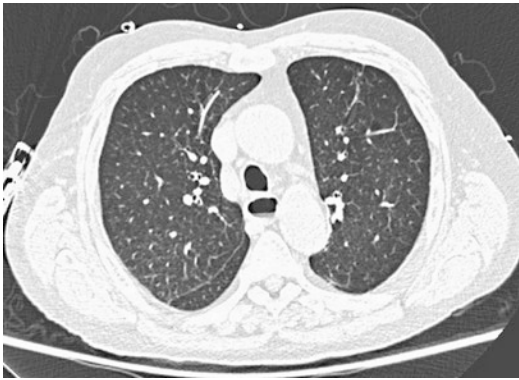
Dilated esophagus with air-fluid level on chest CT
